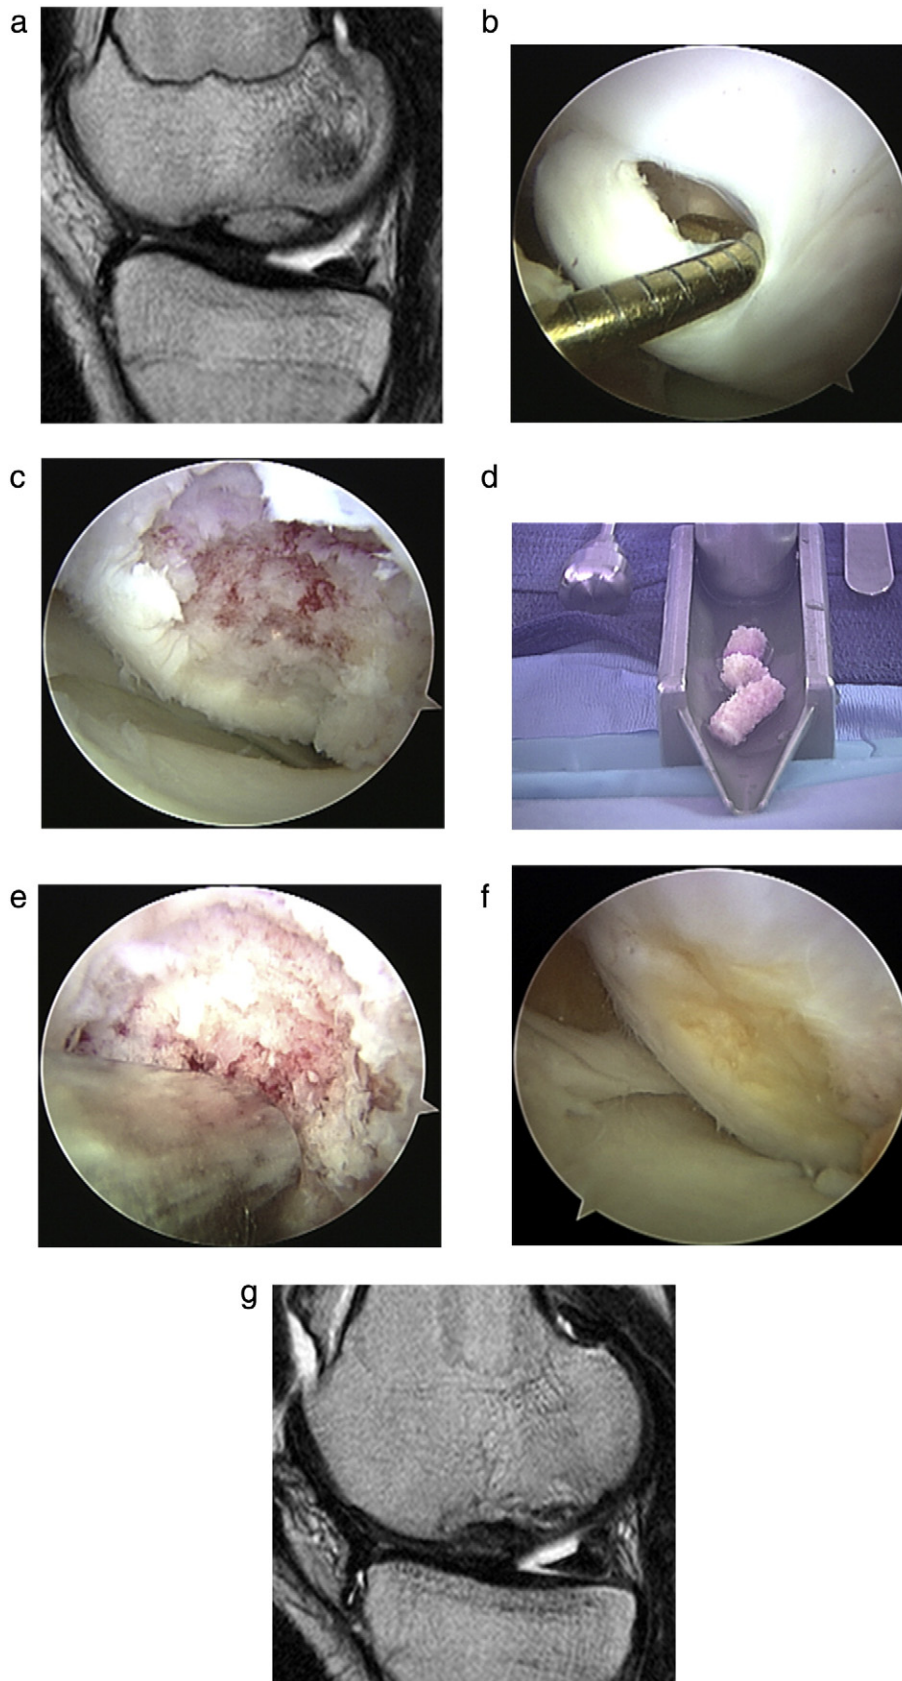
a: Patient 7 was a 16-year-old student at the time of initial osteochondral grafting who had failed to respond to a fixation of an unstable OCD lesion on the MFC. Preoperative sagittal MRI image showing an unstable fragment. b: Arthroscopic image of the unstable fibrous fragment. c: Debridement of defect. d: Harvested osteochondral plugs in graft impactor. e: Paste graft impacted into morselized defect. f: Defect healing 1 year post-operatively. g: 4 year postoperative sagittal MRI image showing defect healing.
